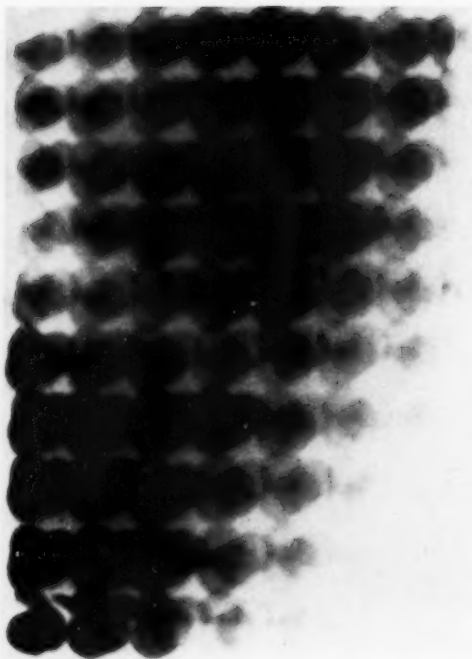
Radiograph of grid field on the chest. Four independent set-ups of the treatment cone.
